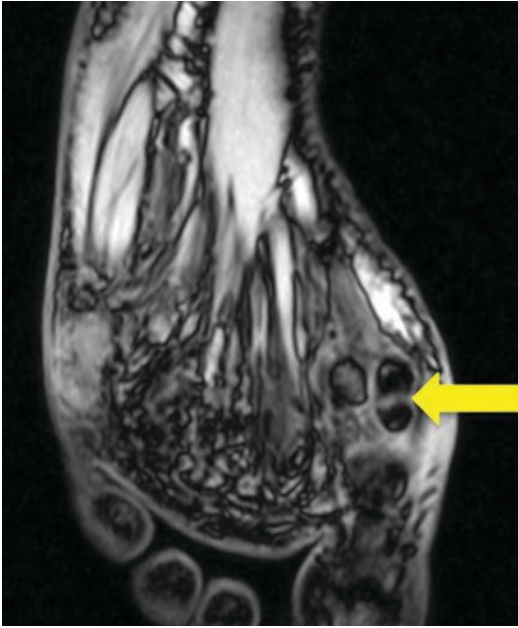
MRI showing a sesamoid stress fracture (yellow arrow)
